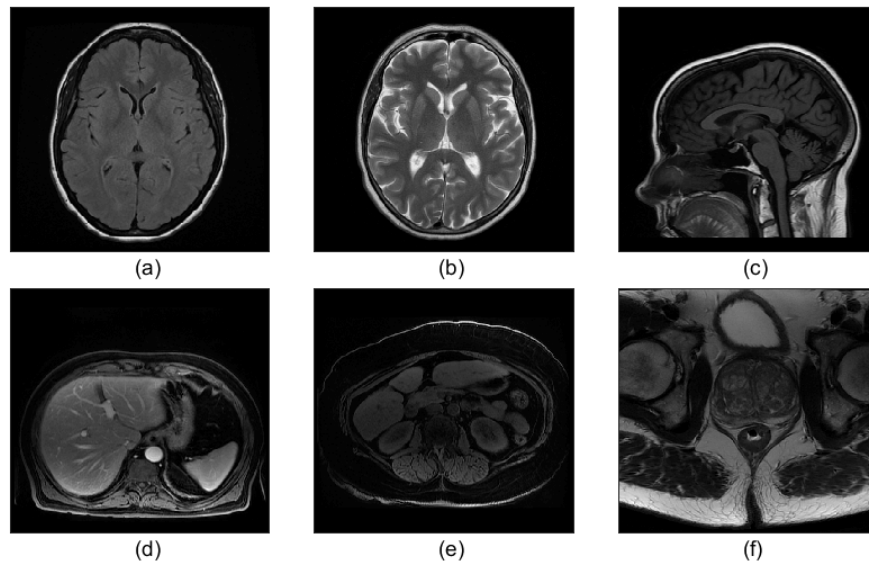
Representative set of reference images. (a) T2 FLAIR, (b) T2 PROPELLER, (c) T1 FLAIR, (d) T1 LAVA-FLEX (post contrast), (e) T1 LAVA-FLEX (pre-contrast), (f) T2 PROPELLER. © 2019 IEEE.
